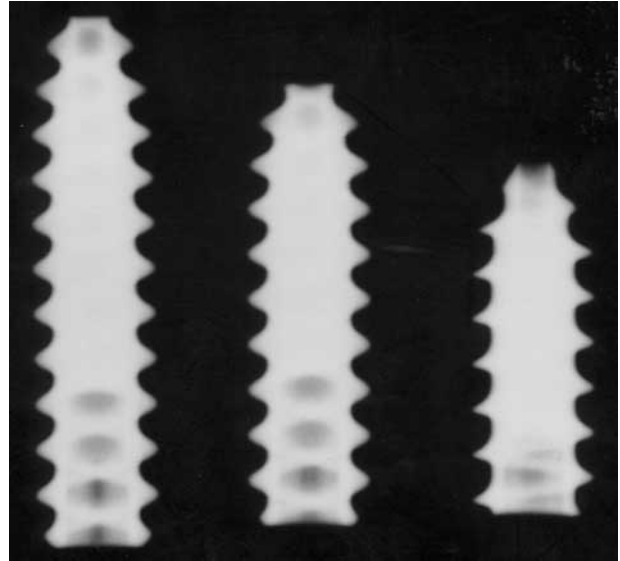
Radiographic views of the Linvatec Propel screws, which are 7 mm in diameter and 20, 25, and 30 mm in length.
